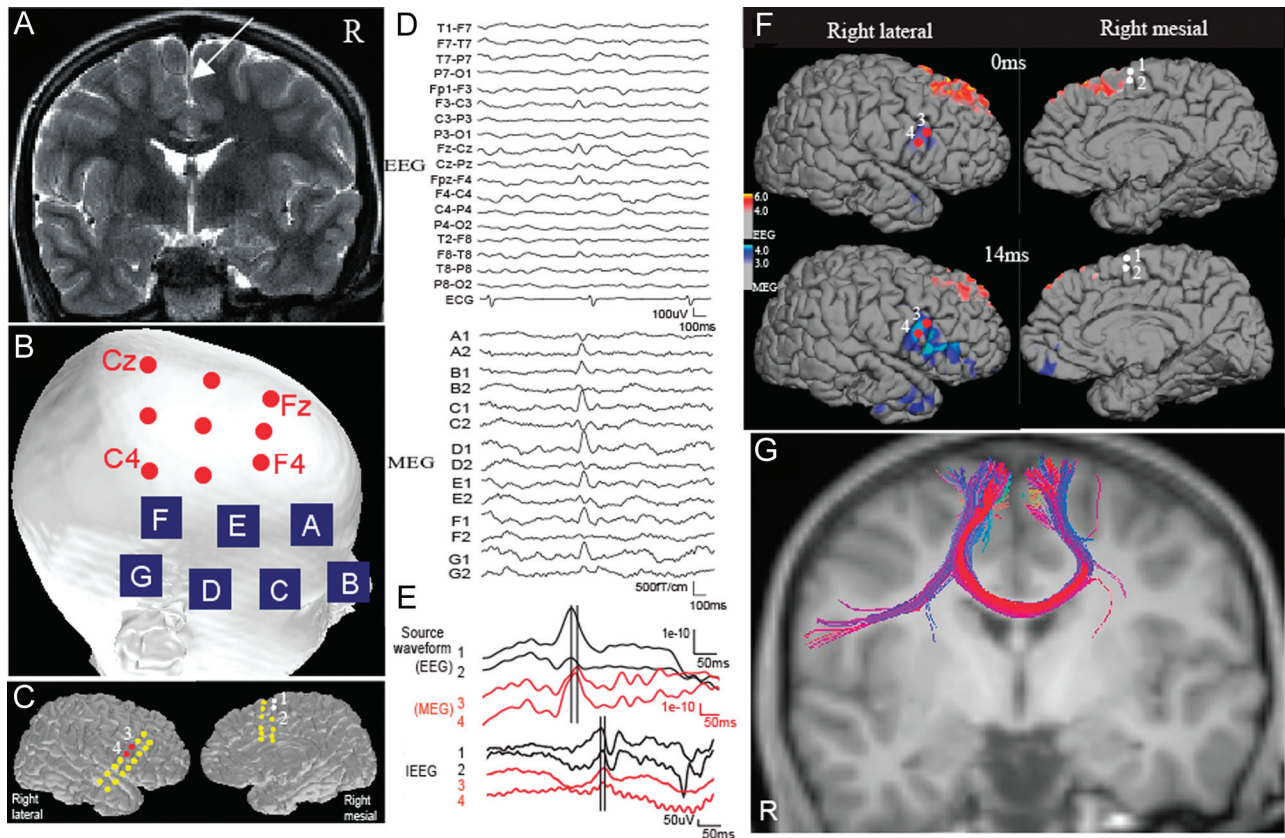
A*, MR image shows a right superior frontal gyrus lesion (arrow). *B*, Active sites that show frequent spikes on EEG and MEG. Red circles and blue squares show EEG electrodes and MEG sensors, respectively. Note that the active MEG electrodes are located more inferiorly than the active EEG electrodes. *C*, The location of grids is shown on the cortical surface. *D*, A typical spike recorded on simultaneous EEG and MEG. The labels of the MEG channels correspond to the sensors shown on *B*. Each site has 2 gradiometers. *E*, Source waveforms of an EEG/MEG spike and a typical spike on IIEEG. Source waveforms are extracted at sites 1 and 2 (superior frontal) for EEG and 3 and 4 (inferior frontal) for MEG. The superior frontal peak of EEG waveforms precedes the inferior frontal peak of MEG waveforms by approximately 20 ms. A similar time difference is seen on the IIEEG spike. *F*, A source distribution map of a typical spike appearing on both EEG and MEG. Cortical activation is shown with red/yellow for EEG and blue/dark blue for MEG. The EEG activation appears in the right superior frontal area at the early latency (0 ms), whereas the MEG source shows later activation in the inferior frontal area (14 ms). White and red circles show the location of active IIEEG electrodes in the superior (sites 1 and 2) and inferior (sites 3 and 4) frontal areas, respectively. *G*, The tractography shows a fiber connection between the right superior and inferior frontal gyri.
